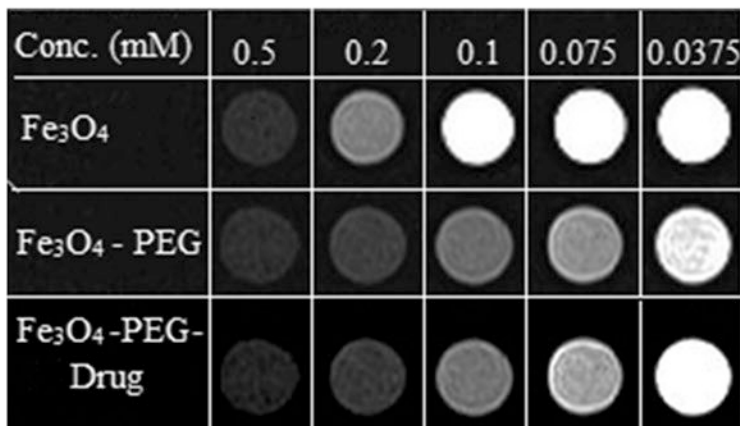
MRI images of Fe_3O_4 , Fe_3O_4 -PEG, and Fe_3O_4 -PEG-drug for Fe conc. of 0.5, 0.2, 0.1, 0.075, and 0.0375 mM in water [14]
